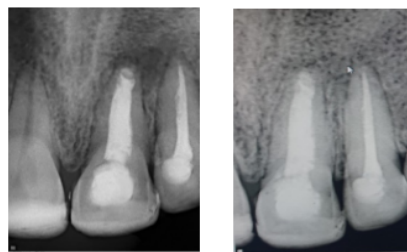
Six months and 1 year follow up radiographs
